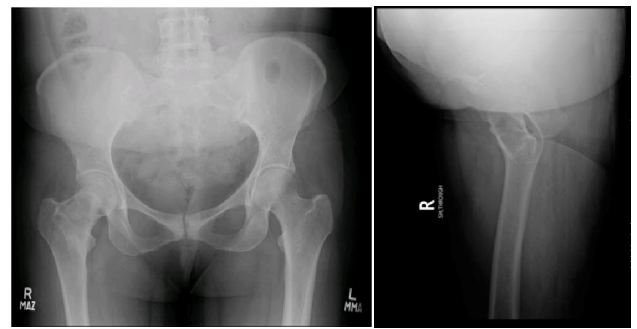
X-ray pelvis: There is a well-defined lucent lesion in the right femoral neck having sclerotic margins but no significant bone expansion. No fracture or periosteal reaction is seen.
